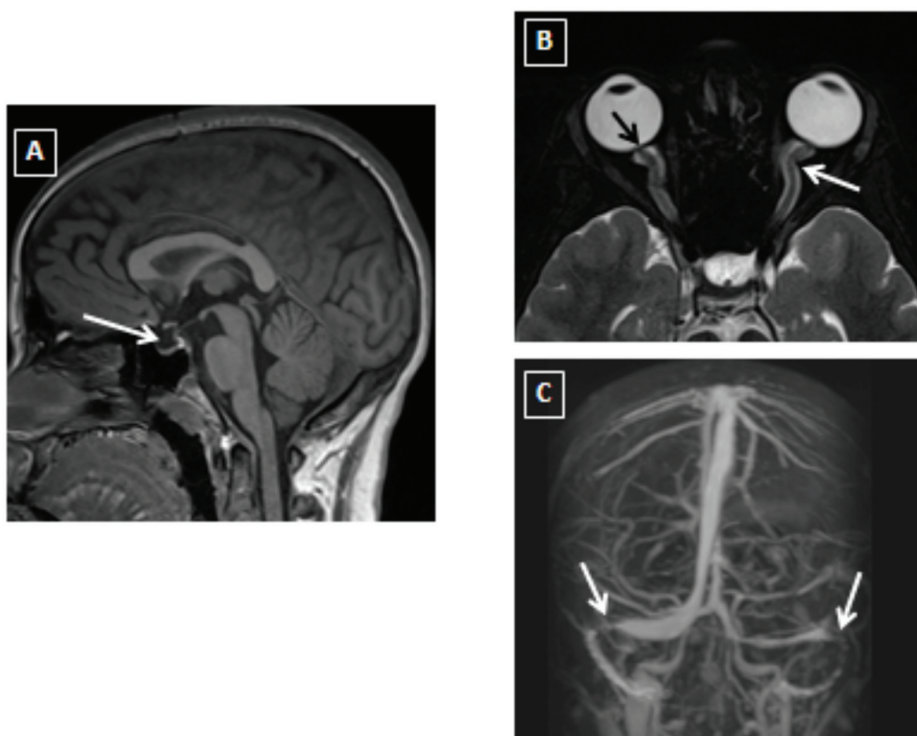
Brain MRI (A, sagittal T1WI) showing partial empty sella (white arrow). Axial T2 fat saturation for orbits (B) showing flattening of posterior globe and prominence of the optic nerve head (black arrow) as well as tortuosity of optic nerve and prominent perioptic nerve sheath (white arrow). MRV (C) showing focal narrowing of bilateral distal transverse sinuses (white arrow).
